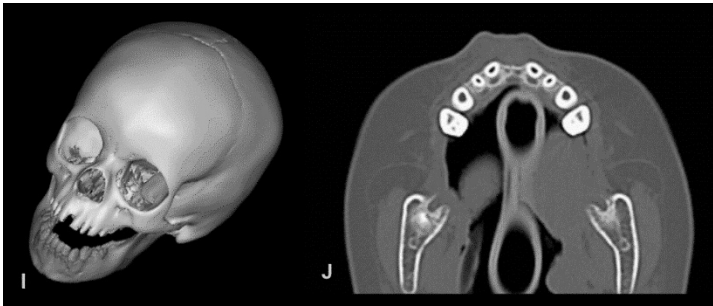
Clinical phenotype of a female patient with Tessier cleft number 0. A-C: at one year and four months old. Observe the mild cleft at the centre of the upper lip extending as a wide groove in the philtrum. A wide nasal base and low nasal bridge were present. D-E: facial phenotype at age five showing a midline diastema between maxillary central incisors. F-I: computed tomography 3D-reconstructions obtained at two years old showing a mild midline groove in the premaxilla. J: computed tomography axial section showing a widened interdental bone septum between the maxillary central incisors.
